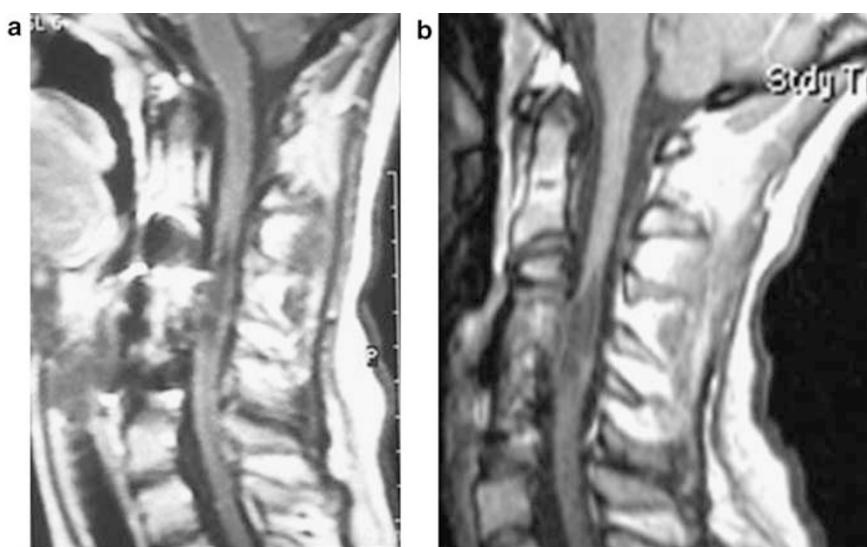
(a) MRI of patient 2 in March 2005. (b) MRI of patient 2 in June 2007. MRI, magnetic resonance imaging.
